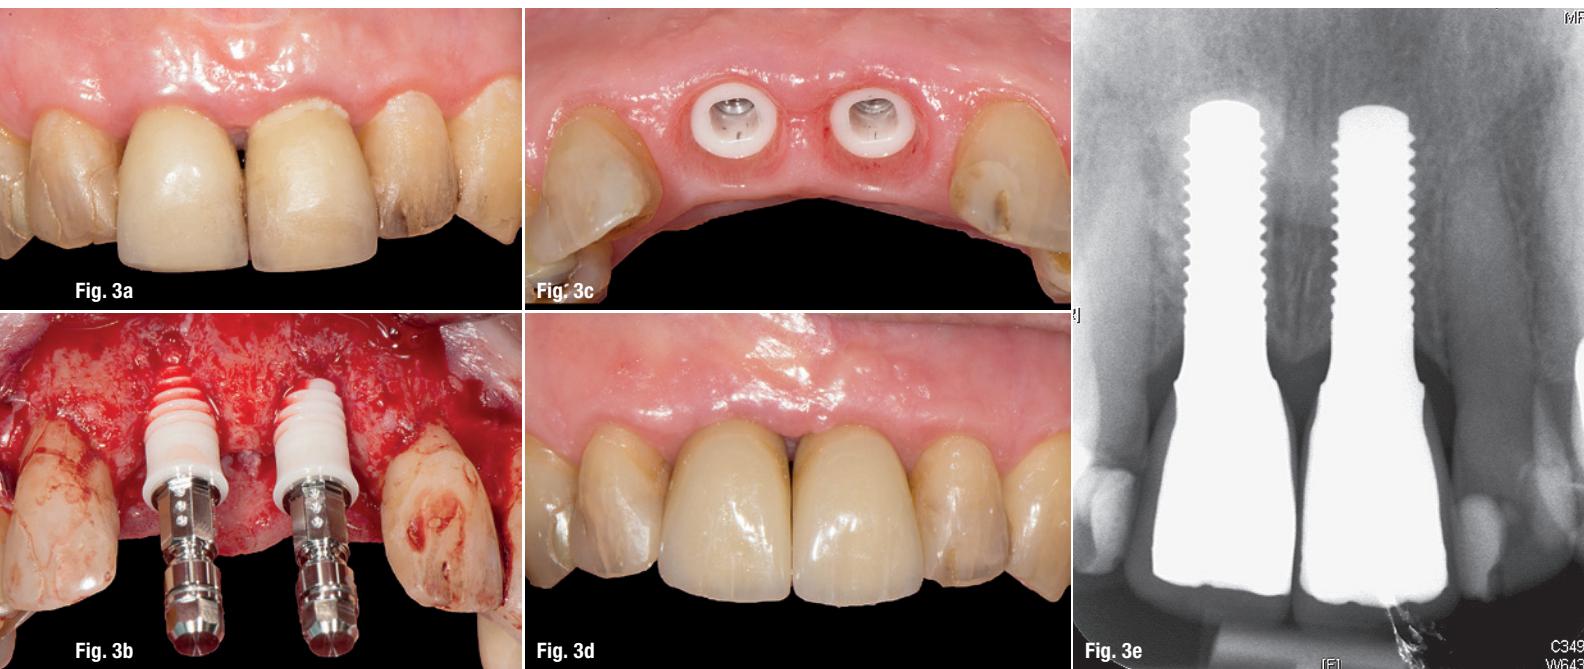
Initial clinical situation: Secondary root caries and longitudinal fractures in teeth #11 and #21 (implant location according to WHO). Fig. 3b: Clinical situation at implant placement eight weeks after tooth extraction. Two-piece zirconia implant (PURE Ceramic Implant, Straumann) with metal transfer piece. Fig. 3c: Clinical situation five months after implant placement. Delivery of definitive crown. Fig. 3d: Clinical situation at delivery of definitive screw-retained crown. Fig. 3e: Radiographic control at delivery of definitive crown.
